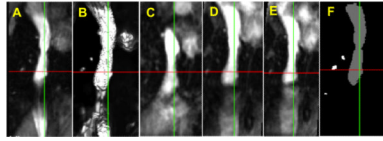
Registration result for inferior vena cava (IVC) in MRI image of lamb. A Reference blood vessel, B Vesselness image, C Result of non-weighted registration, D Result of single-weighted registration, E Result of dual-weighted registration, F Manually segmented region from A.
